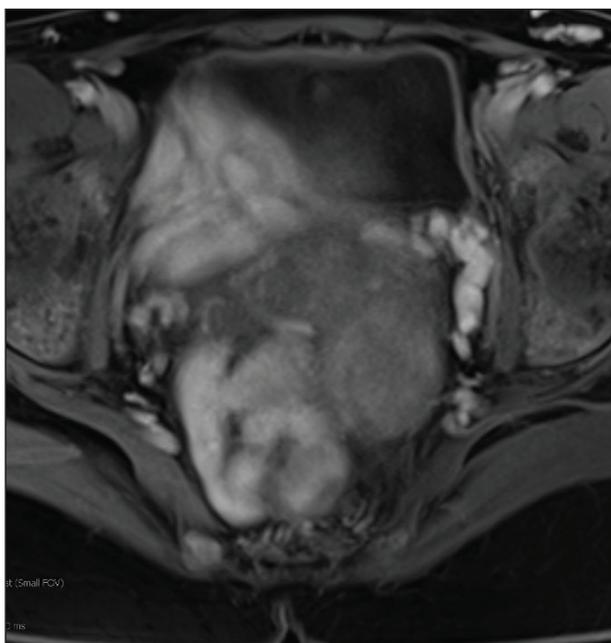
Preintervention MRI postcontrast T1 image showing engorged left parametrial veins.
